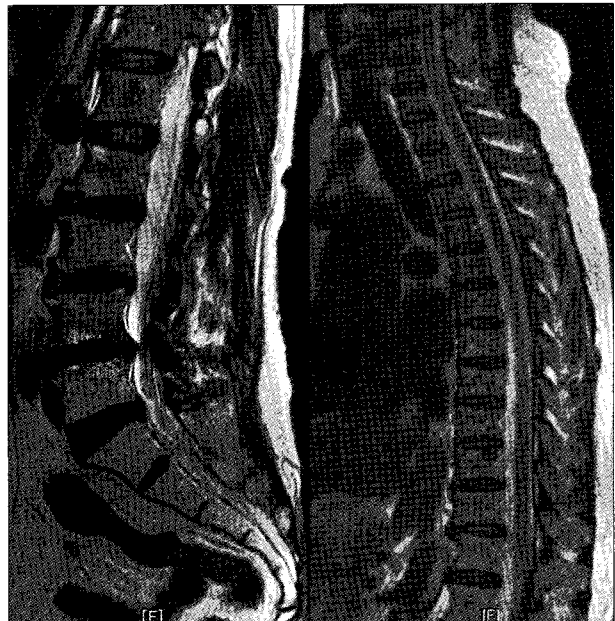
Lumbar and thoracic spine T2-weighted magnetic resonance image showing no abnormality on thracolumbar area.
